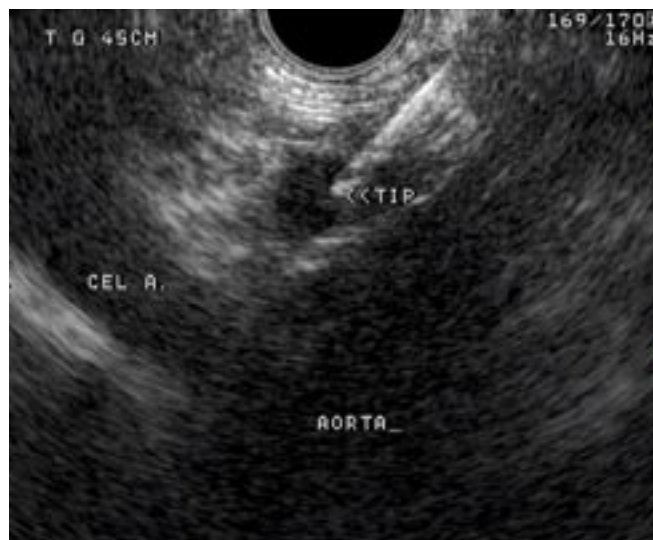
Endoscopic Ultrasound View of the Aorta and Celiac Artery
